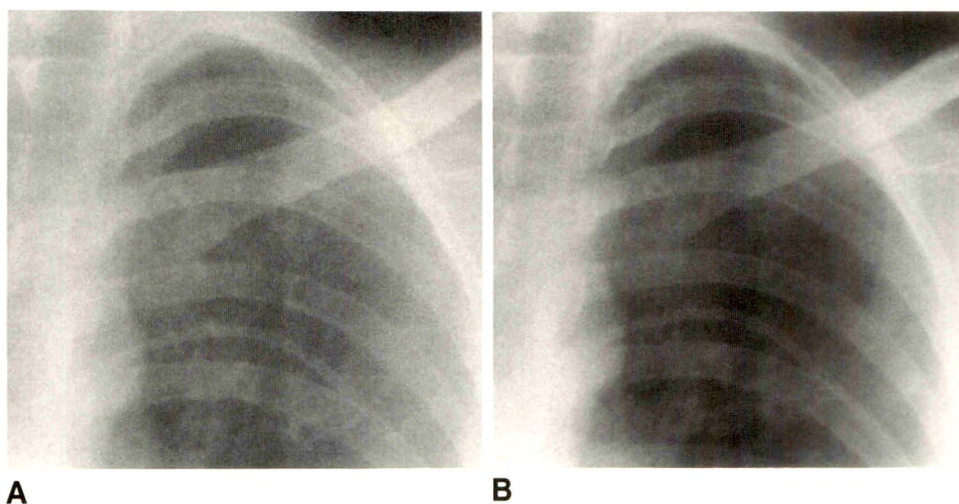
A, Original chest radiograph of 29-year-old woman with left apical pneumothorax. Small chest catheter is in place.
